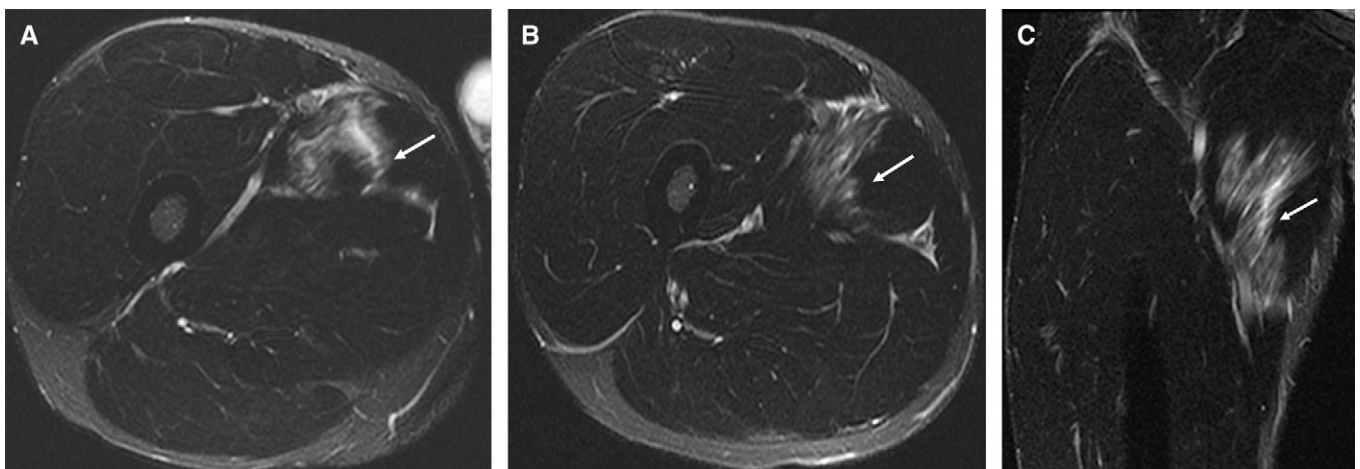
Adductor longus muscle injury. (A, B, C) Axial and coronal fat-saturation fast spin-echo T2-weighted magnetic resonance imaging, demonstrating a grade 2 muscle tear of the proximal adductor longus muscle (white arrows), which demonstrates 50%–60% circumferential involvement of the muscle belly. The craniocaudal extent of the tear measures approximately 16 cm. The patient received nonsurgical treatment and returned to professional hockey.
